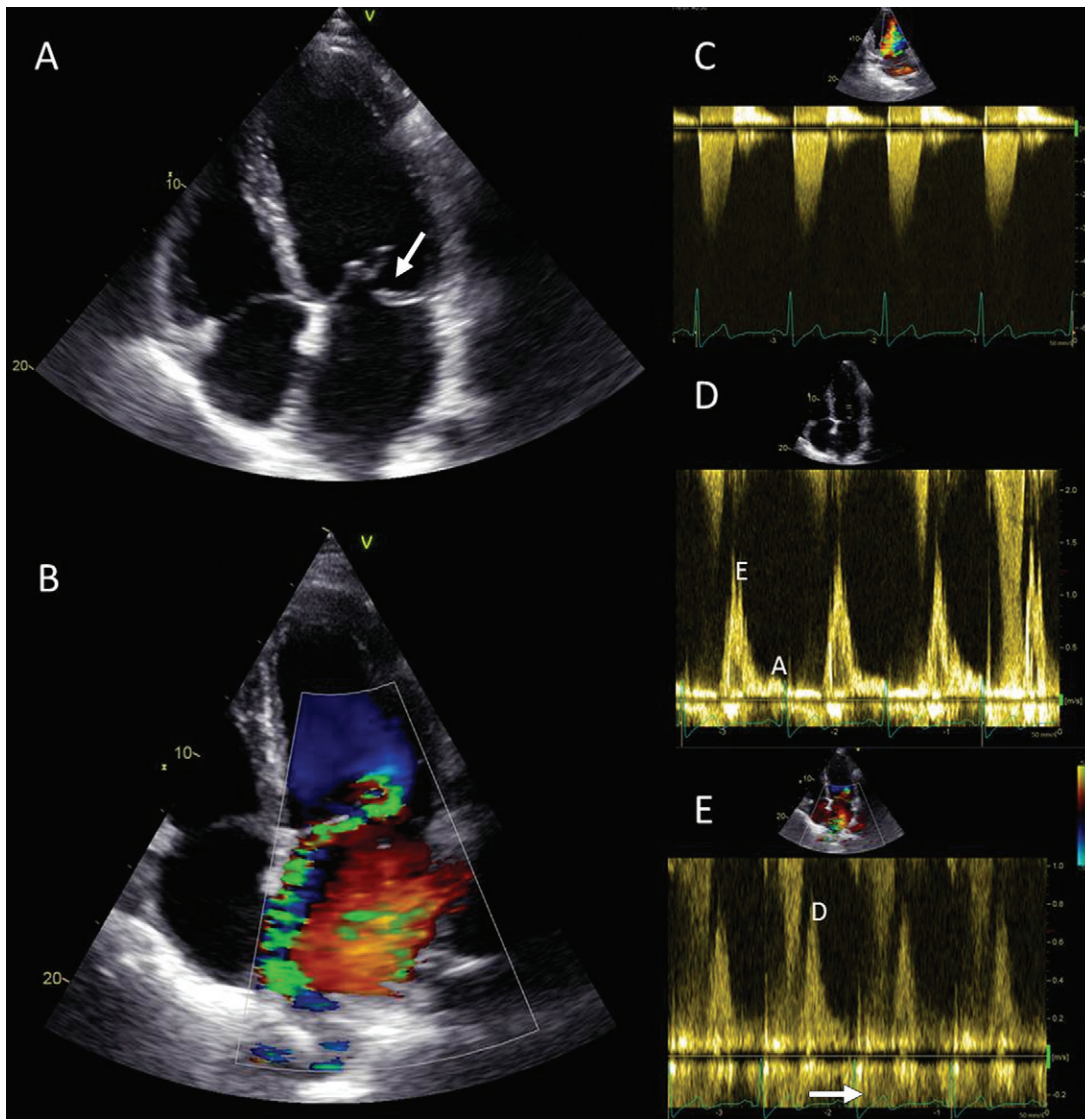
Assessment of mitral regurgitation with echocardiography. *A*, Four-chamber transverse echocardiography image in a 63-year-old man with severe mitral regurgitation caused by prolapse of the posterior mitral leaflet (arrow) leading to an eccentric regurgitant jet toward the interatrial septum on *B*, color flow Doppler scan. On *C*, continuous wave Doppler, the spectral Doppler signal is dense and triangular and on *D*, pulsed wave Doppler, note the prominent early diastolic (*E*) wave over the late diastolic (*A*) wave on transmitral flow and, *E*, the systolic flow reversal of the pulmonary vein flow (arrow) followed by the diastolic flow (*D*).
